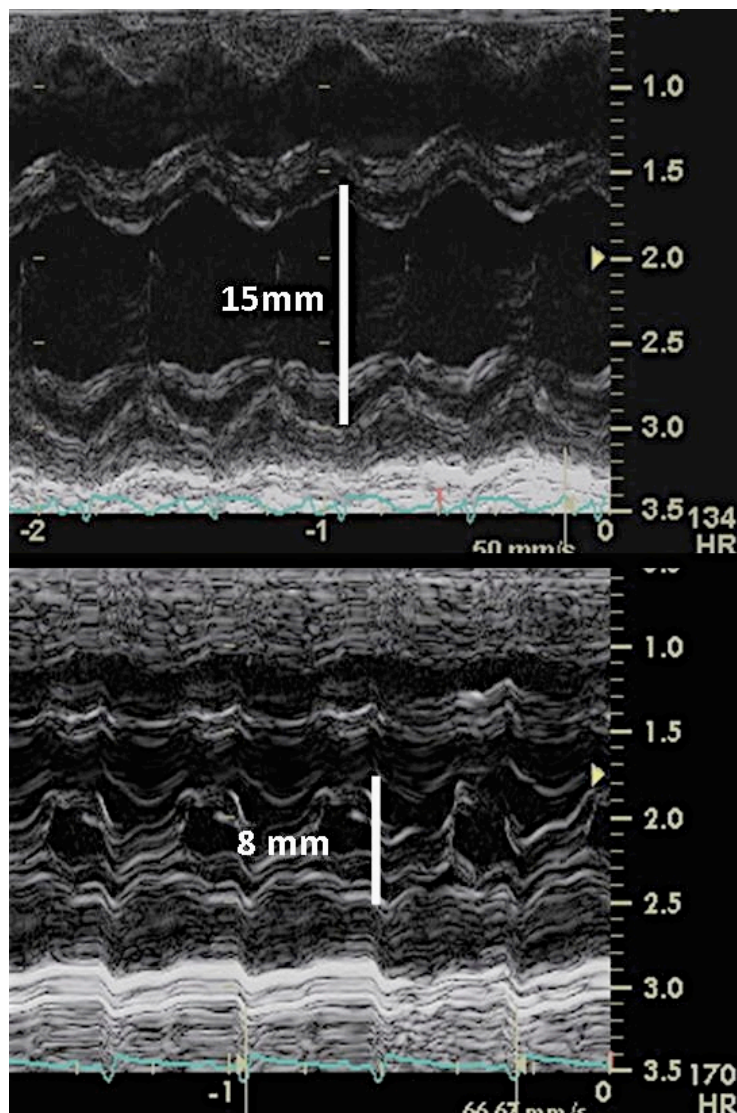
M-mode echocardiography images demonstrating changes in left ventricular cavity size before (Upper Panel) and after (Lower Panel).
